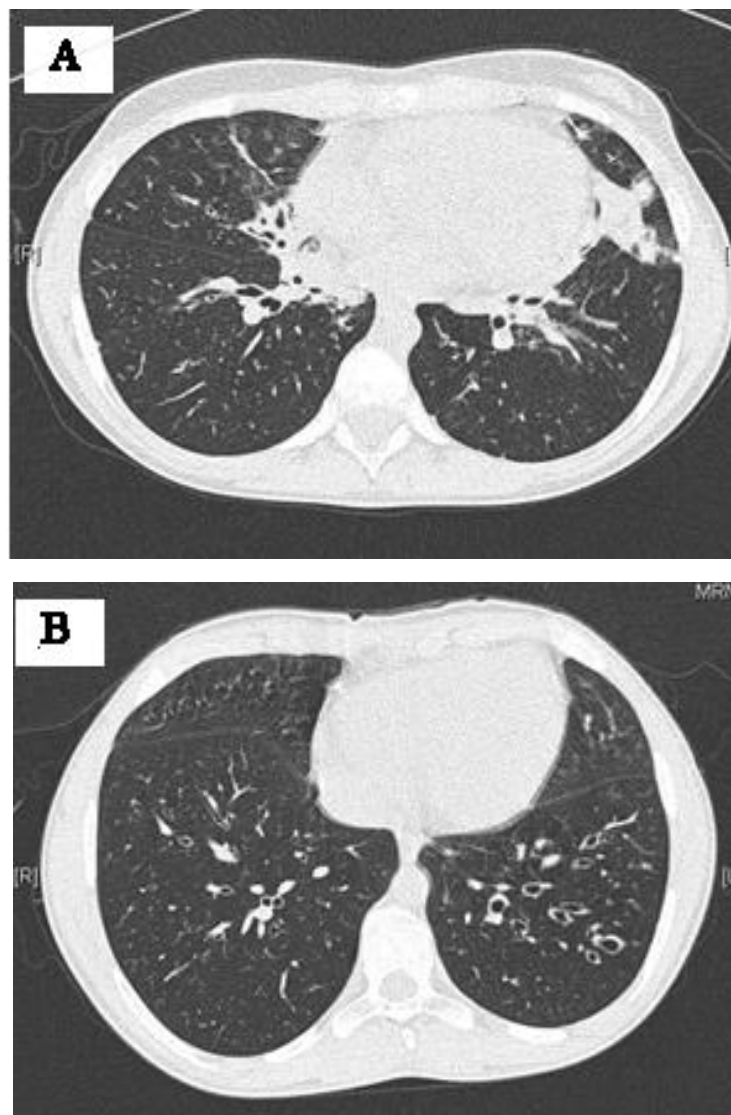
High-resolution computed tomography images for case A and case B pretreatment with orally administered ivacaftor. Case A microbiology: *Mycobacterium abscessus*, *Stenotrophomas maltophilia*, allergic bronchopulmonary aspergillosis in remission. Case B microbiology: Intermittent *Pseudomonas Aeruginosa* and previous *Achromobacter xylosoxidans*.
